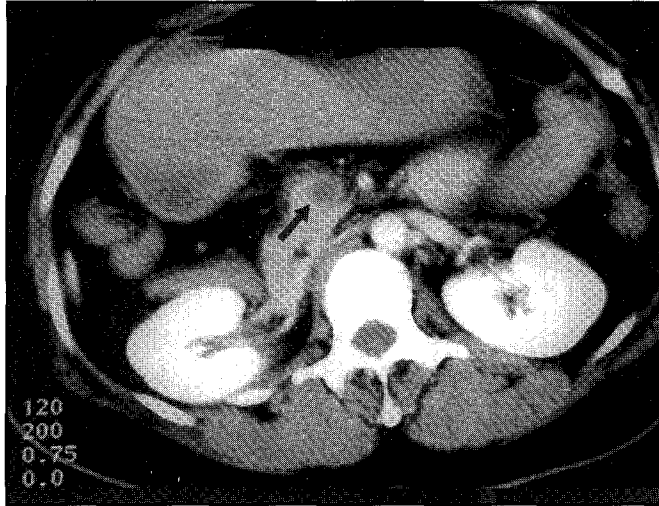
Contrast enhanced spiral CT section at portal-venous phase at the region of head of pancreas showing filling defects (arrow) in superior mesenteric vein indicating thrombosis.
